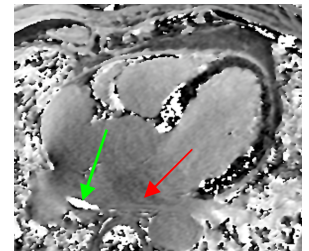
(b) Phase image of DE-MRI scan
